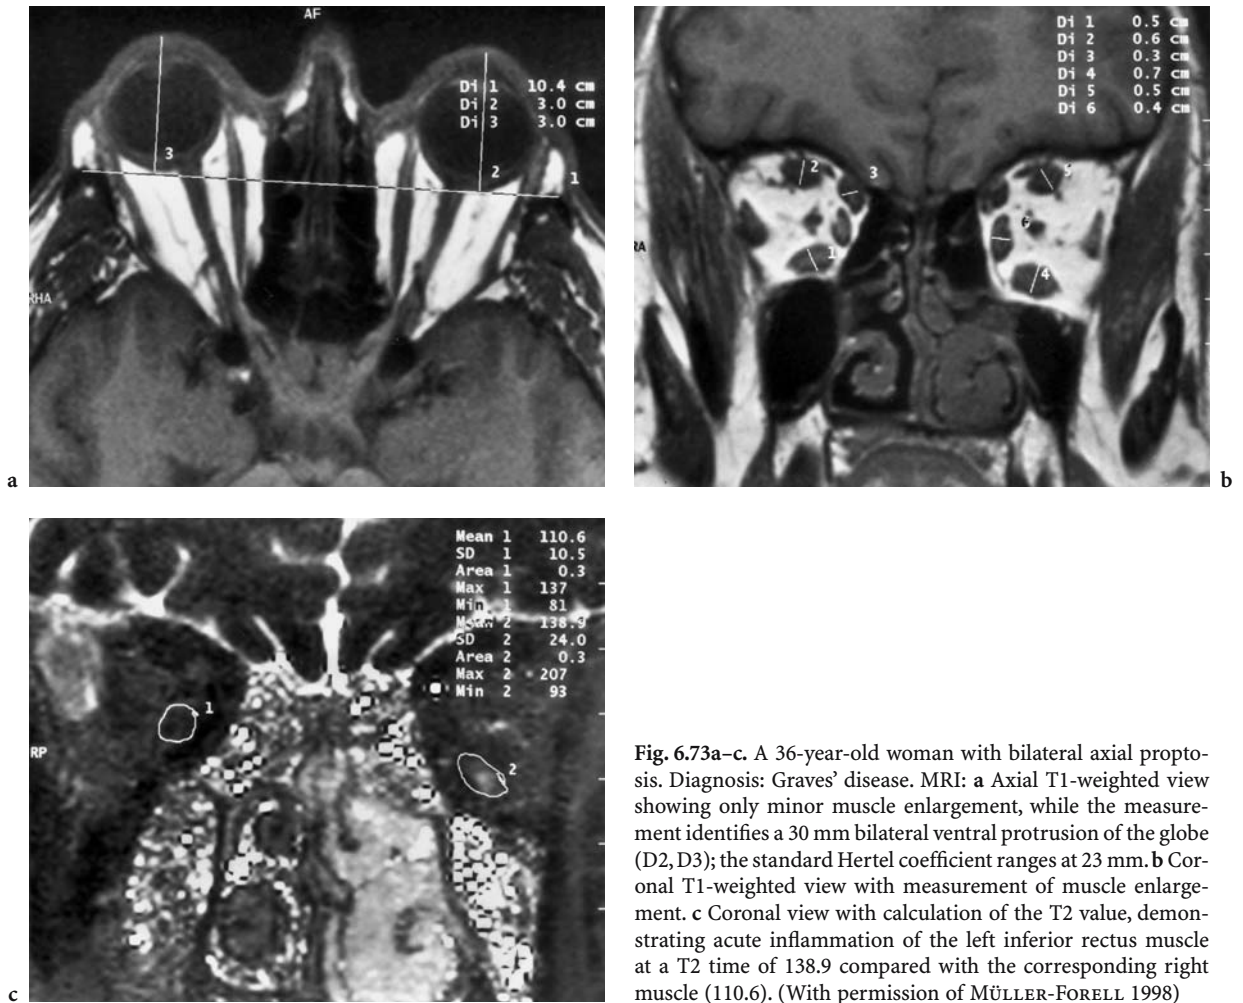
A 36-year-old woman with bilateral axial proptosis. Diagnosis: Graves' disease. MRI: a Axial T1-weighted view showing only minor muscle enlargement, while the measurement identifies a 30 mm bilateral ventral protrusion of the globe (D2, D3); the standard Hertel coefficient ranges at 23 mm. b Coronal T1-weighted view with measurement of muscle enlargement. c Coronal view with calculation of the T2 value, demonstrating acute inflammation of the left inferior rectus muscle at a T2 time of 138.9 compared with the corresponding right muscle (110.6). (With permission of MÜLLER-FORELL 1998)
